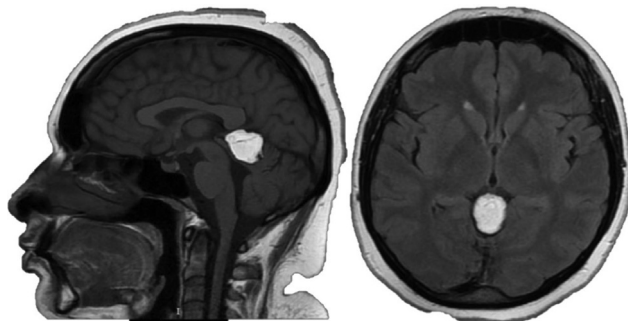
Brain MRI FLAIR weighted image.
